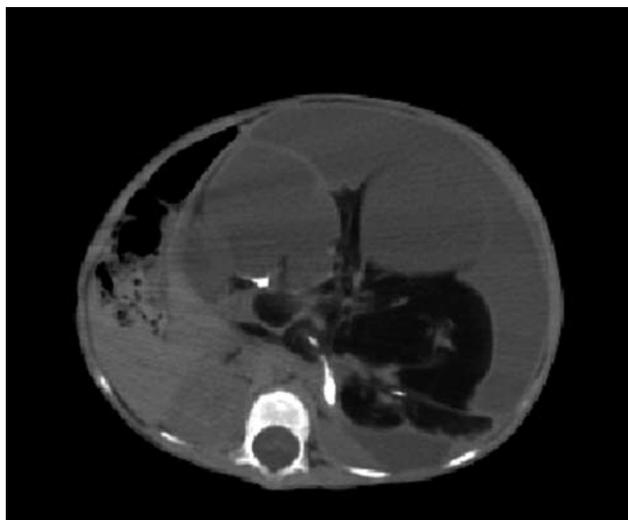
Computer tomography scan (CT) suggesting the presence of a cyst with solid components.
